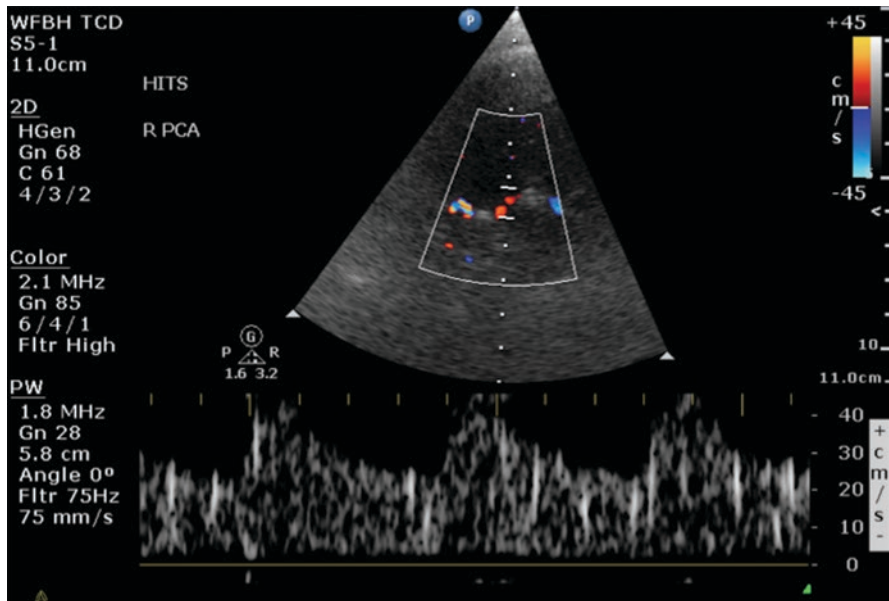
An example of high-intensity transient signals (HITS) visualized on transcranial Doppler imaging of posterior cerebral artery. HITS are solid or gaseous microemboli within the blood flow and are represented by unidirectional short-term intensity increases
